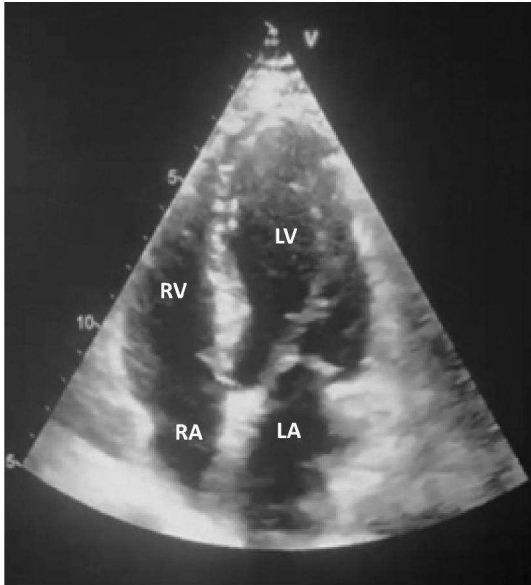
Apical 4 chamber view showing the LA, LV, RA and RV. This view gives a good estimate of ventricular function and size.
